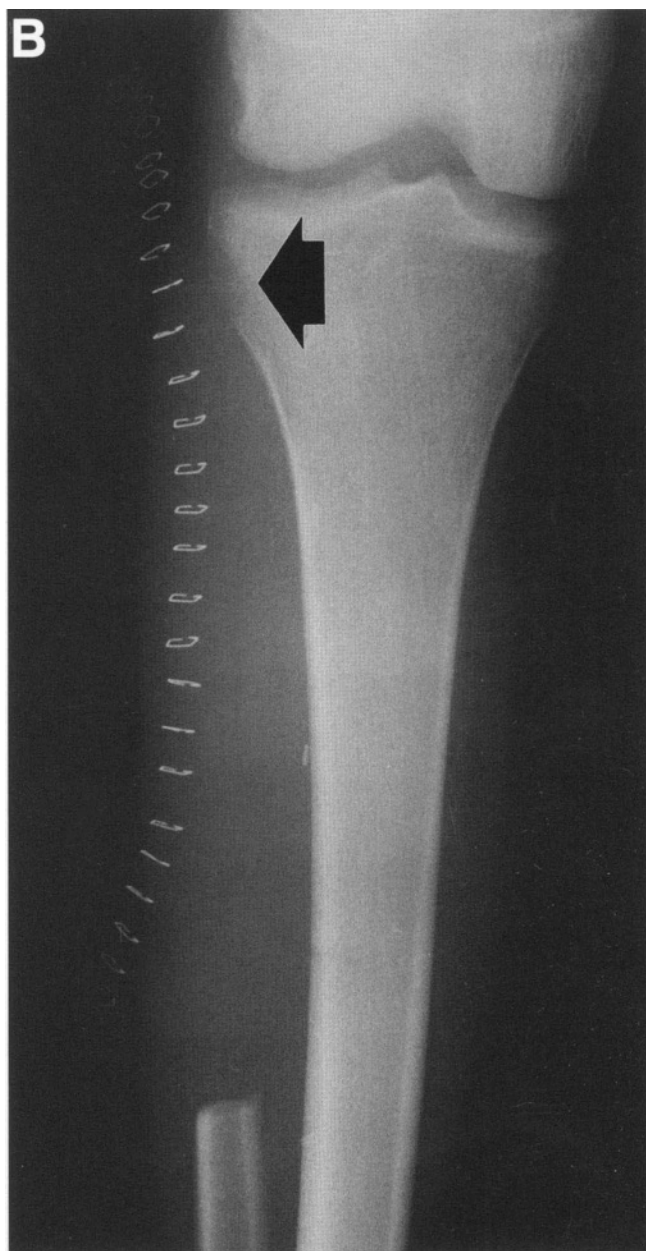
(A) Extent of resection. A Type II resection includes the proximal two-thirds of the fibula, the anterior tibial muscle compartments, and a portion of the soleus muscle which attaches to the fibula as well as the peroneal nerve. (Clin Orthop 1984;186:172–181). (B) Postoperative radiograph following a Type II fibular resection. *Note:* a portion of the adjacent lateral tibial metaphysis has been removed (arrow) indicating an extra-articular proximal tibio-fibular joint resection was performed.
